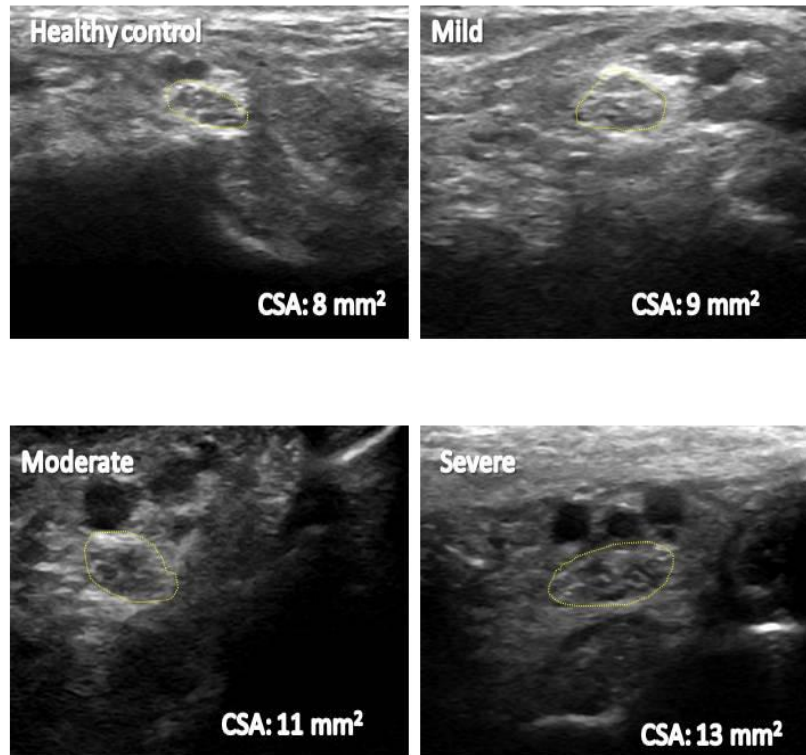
Sonogram of the tibial nerve at medial malleolus (transverse view) of healthy controls and DM patients with different neuropathy severity showing a hypoechoic structure with hyperechoic dots within.
